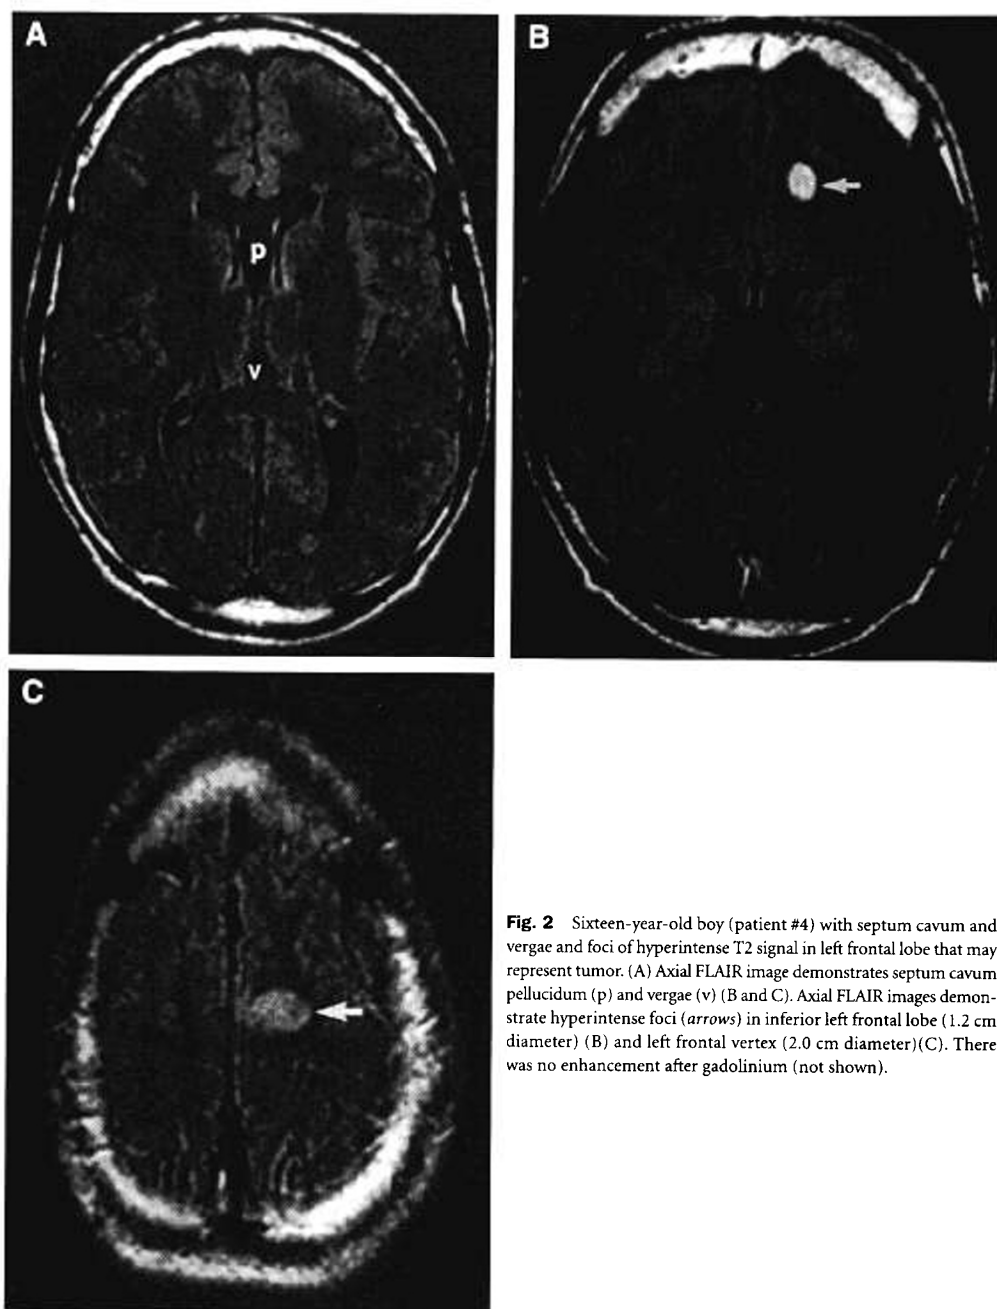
Sixteen-year-old boy (patient #4) with septum cavum and vergae and foci of hyperintense T2 signal in left frontal lobe that may represent tumor. (A) Axial FLAIR image demonstrates septum cavum pellucidum (p) and vergae (v) (B and C). Axial FLAIR images demonstrate hyperintense foci (arrows) in inferior left frontal lobe (1.2 cm diameter) (B) and left frontal vertex (2.0 cm diameter)(C). There was no enhancement after gadolinium (not shown).
